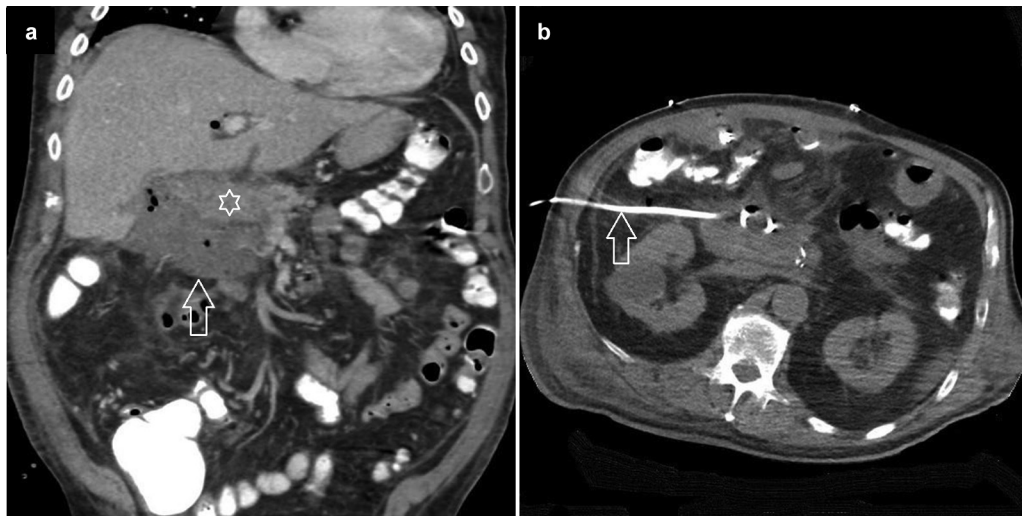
Patient post pancreaticoduodenectomy with leakage at the pancreatic-intestinal anastomosis. (a) Coronal CT demonstrating a collection (arrow) inferior to the pancreas (star). (b) Axial CT demonstrating successful drain placement (arrow), avoiding the liver, colon, and right kidney.
